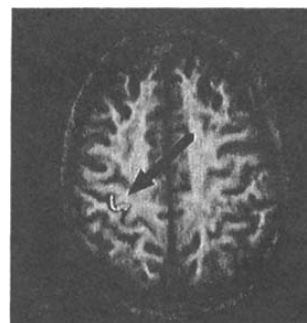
Overlay of filtered EPISTAR difference image onto T1-weighted image localizes increased blood flow to anterior bank of central sulcus (motor cortex).
